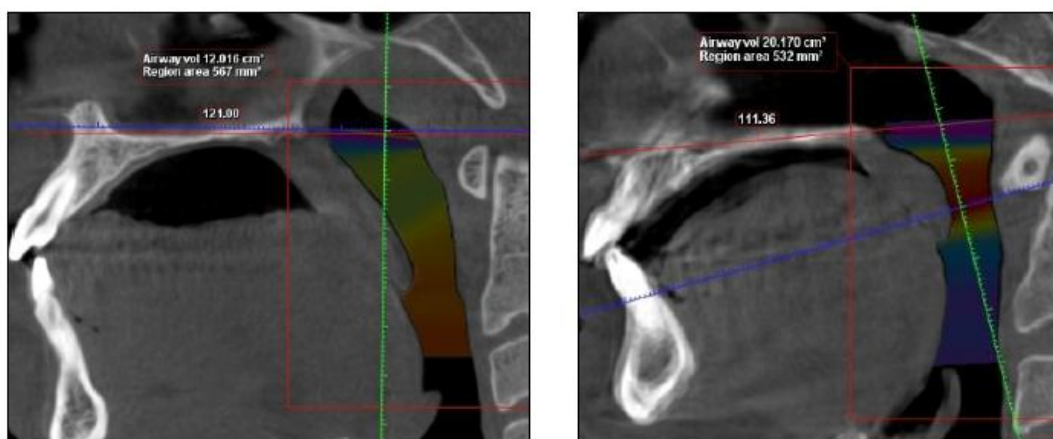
Airway space volume of OSMF subject and non OSMF subject assessed on CBCT
